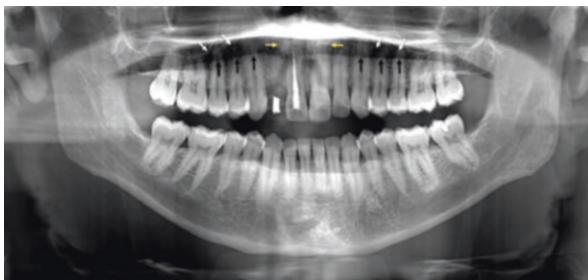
Panoramic radiograph taken for the initial evaluation of the edentulous space at the site of missing tooth #7. Note the extent of superimposition of adjacent anatomic structures. Superimposition of the soft tissue of the nose (*colored arrows*), dorsum of the tongue (*black arrows*), and the oral airway space (*white arrows*) are indicated
